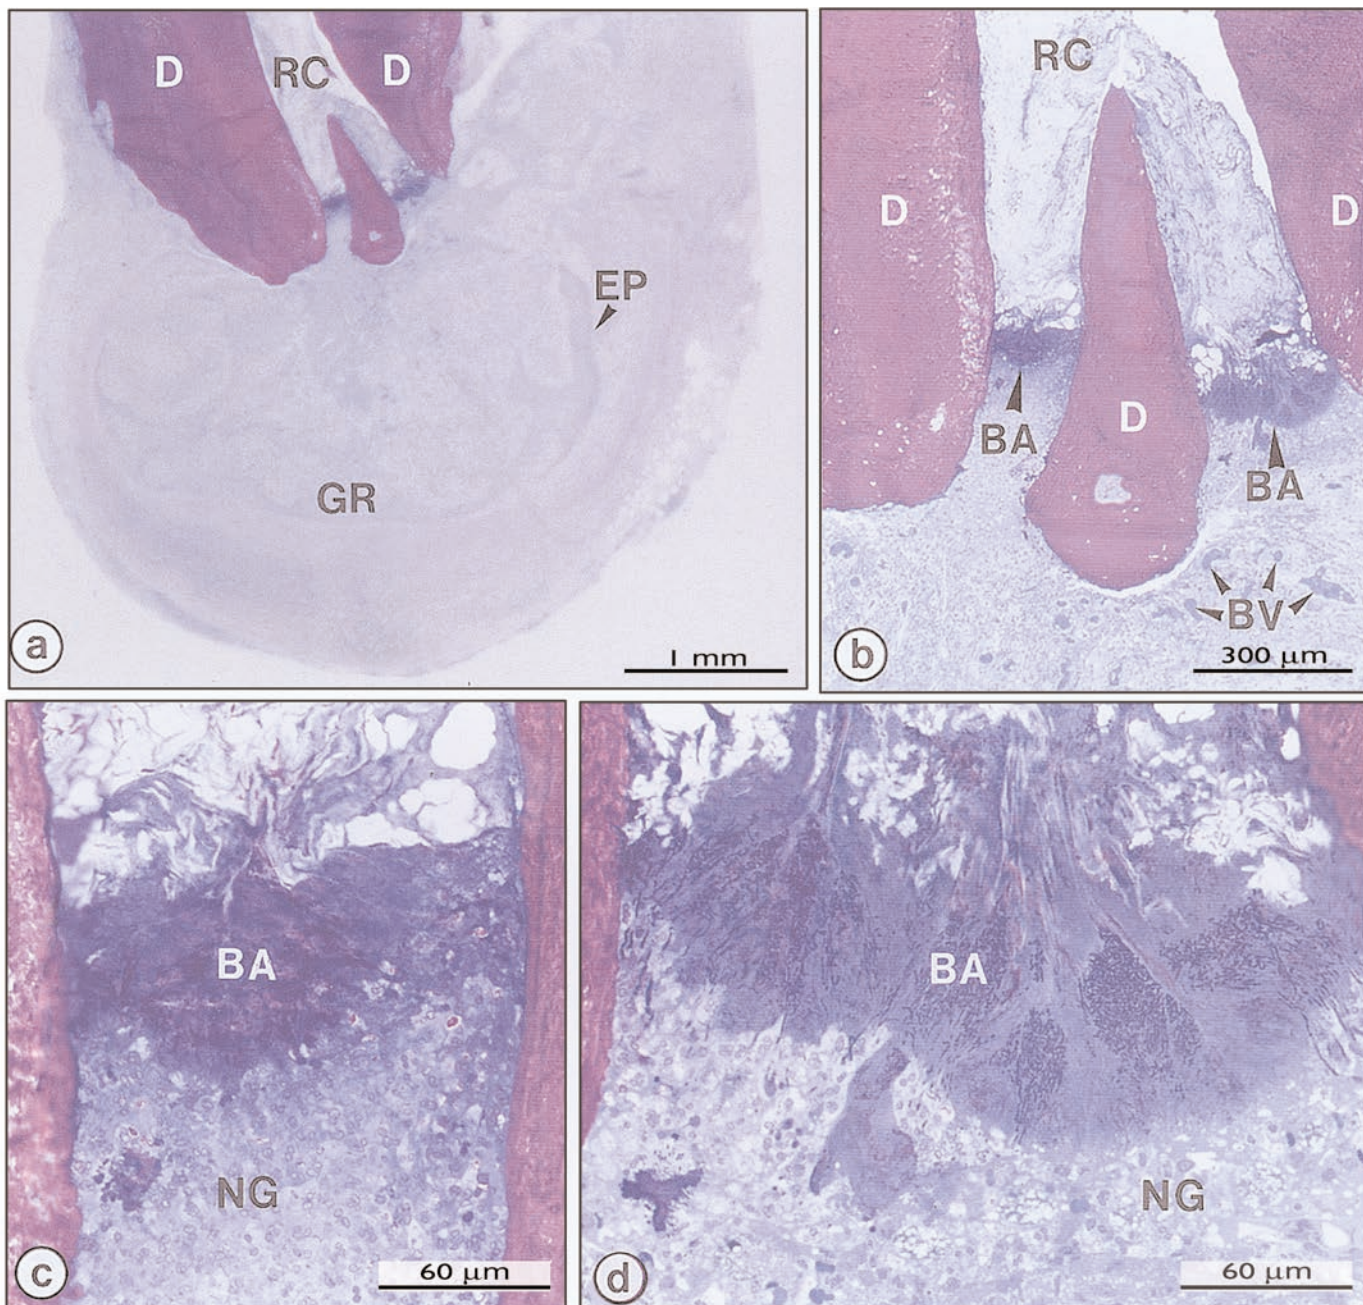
Well-entrenched biofilm at the apical foramen of a tooth affected with apical periodontitis (GR). The apical delta in (a) is magnified in (b). The canal ramifications on the left and right in (b) are magnified in (c) and (d), respectively. Note the strategic location of the bacterial clusters (BA) at the apical foramina. The bacterial mass appears to be held back by a wall of neutrophilic granulocytes (NG). Obviously, any surgical and/or microbial sampling procedures of the periapical tissue would contaminate the sample with the intraradicular flora. EP, epithelium. Magnifications: (a) 20x, (b) 65x, and (c,d) 350x. (From Nair, 2002.)
